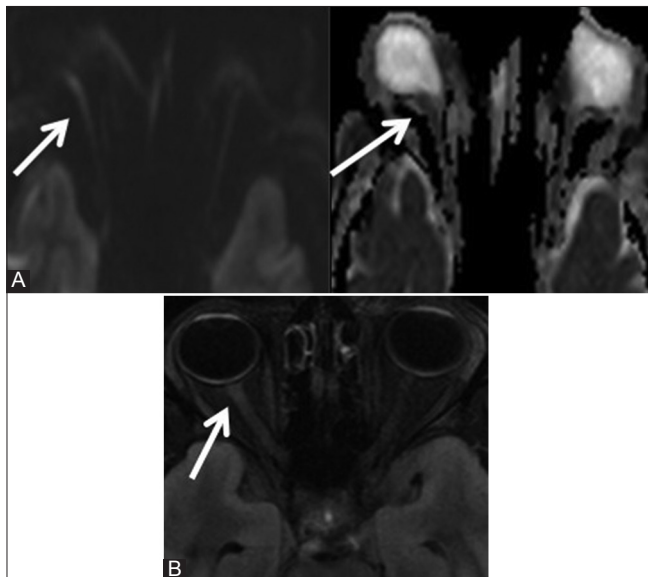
(A and B): Ischemic: DWI (A) and FLAIR (B) images of a 45-year-old female with sudden loss of right vision after cholecystectomy surgery 4 days back show restricted diffusion in right optic nerve (arrow) with hyperintense signal on FLAIR image
